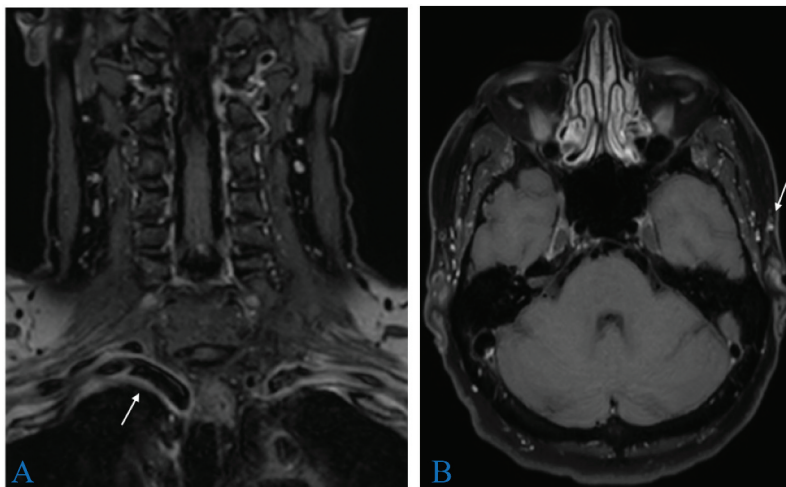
Magnetic resonance imaging findings indicative of giant cell arteritis during relapse. (A, B) T1-weighted three-dimensional black-blood magnetic resonance images with gadolinium contrast demonstrating wall enhancement in (A) the right brachiocephalic artery in the coronal view and (B) the proximal segments of the left temporal artery, including its frontal branches, in the axial view.
